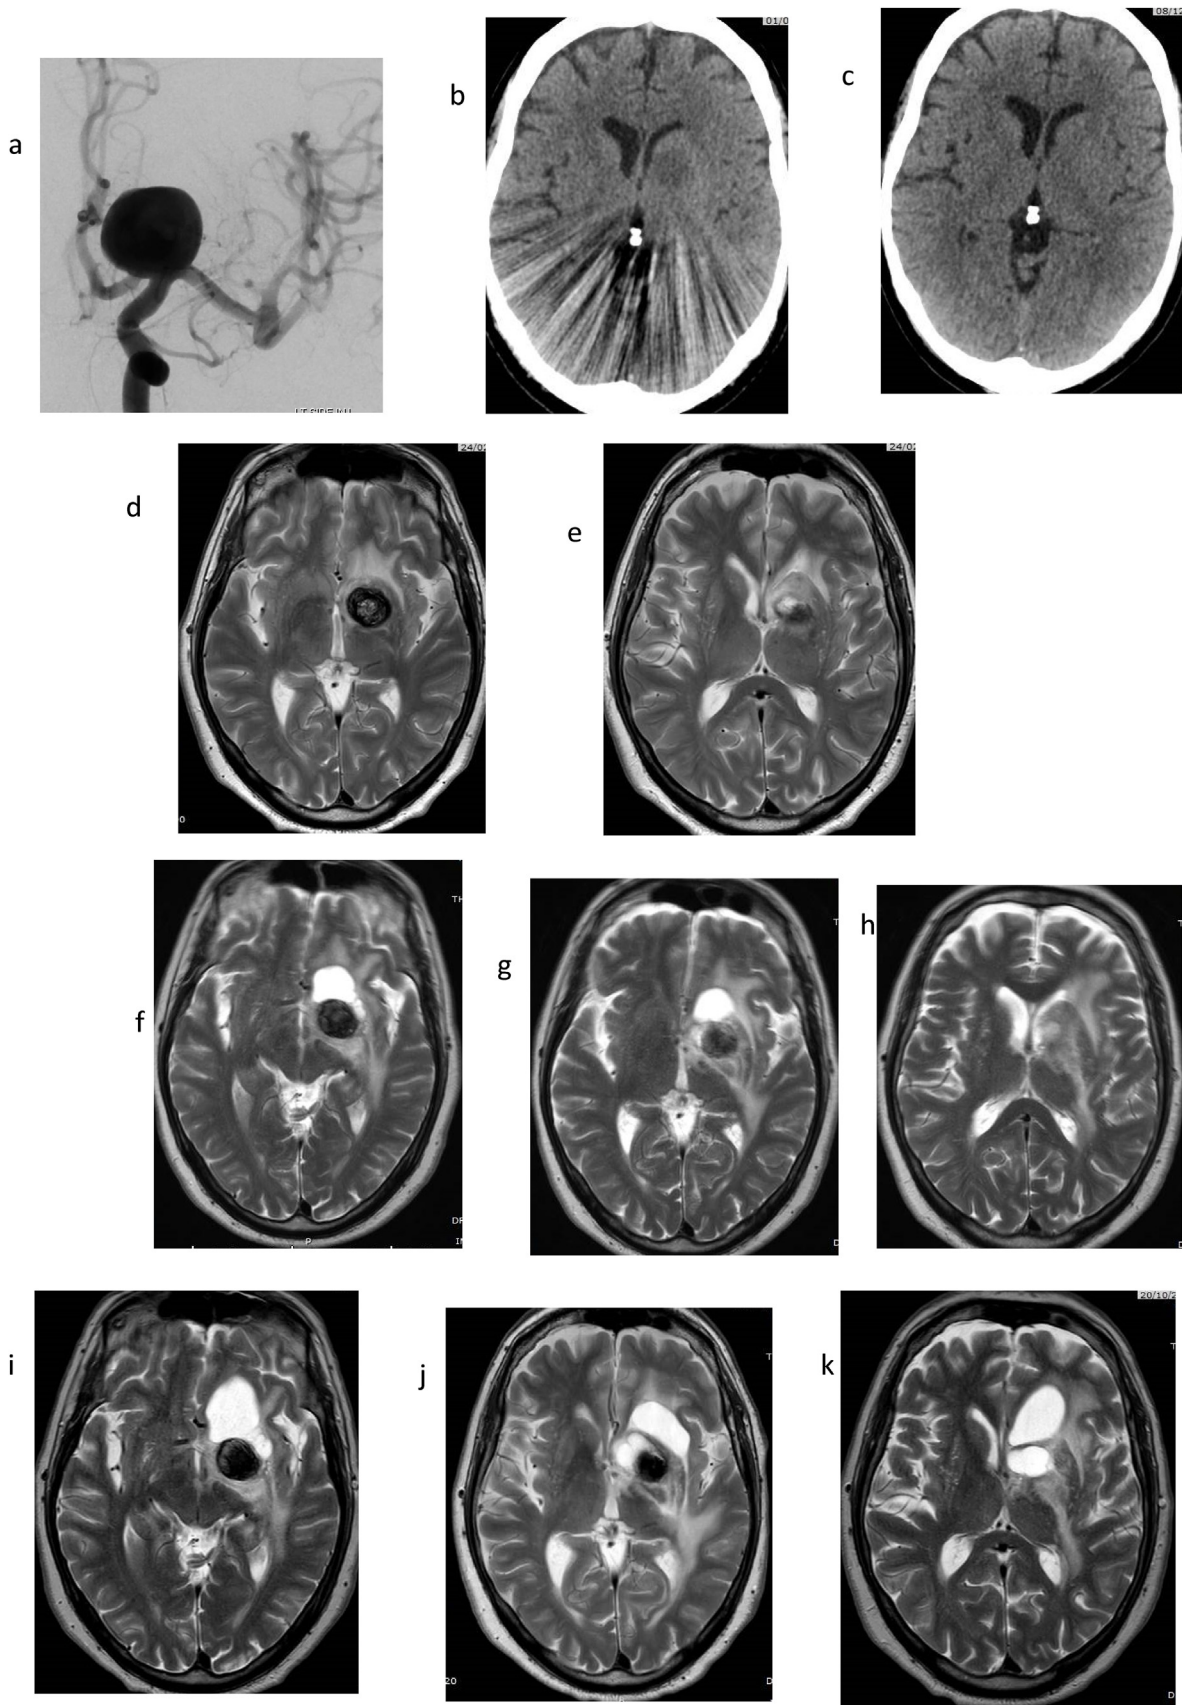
Frontal projection of a left internal carotid angiogram (a) demonstrates a large terminal internal carotid artery aneurysm. Axial unenhanced cranial CT scans (b,c), the day after embolisation, show a small amount of oedema in the left basal ganglia. T2W axial MR images one month (d,e), 12 months (f,g,h) and 33 months after embolisation (i,j,k) show progressive oedema, development and enlargement of the perineurysmal cysts.
